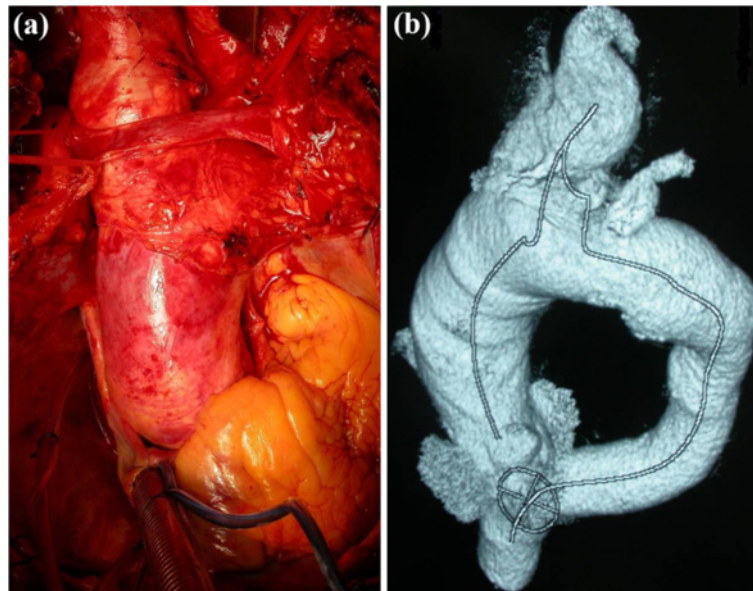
(a) Intra-operative finding of a large IA aneurysm extending into the aortic arch (b) Pre-operative 3D CT reconstruction of the aneurysmal segment.
